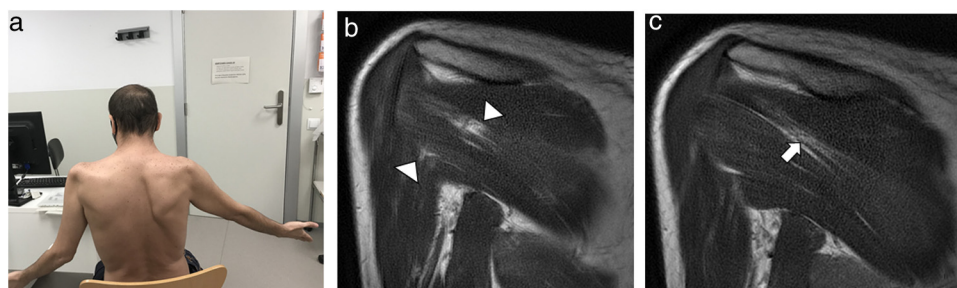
a) Patient with right scapular winging and limited range of shoulder movement. b) T1-weighted MRI sequence of the shoulder. Oedema of the bellies of the right infraspinatus and teres major muscles. c) Fatty infiltration in the belly of the right infraspinatus muscle.
